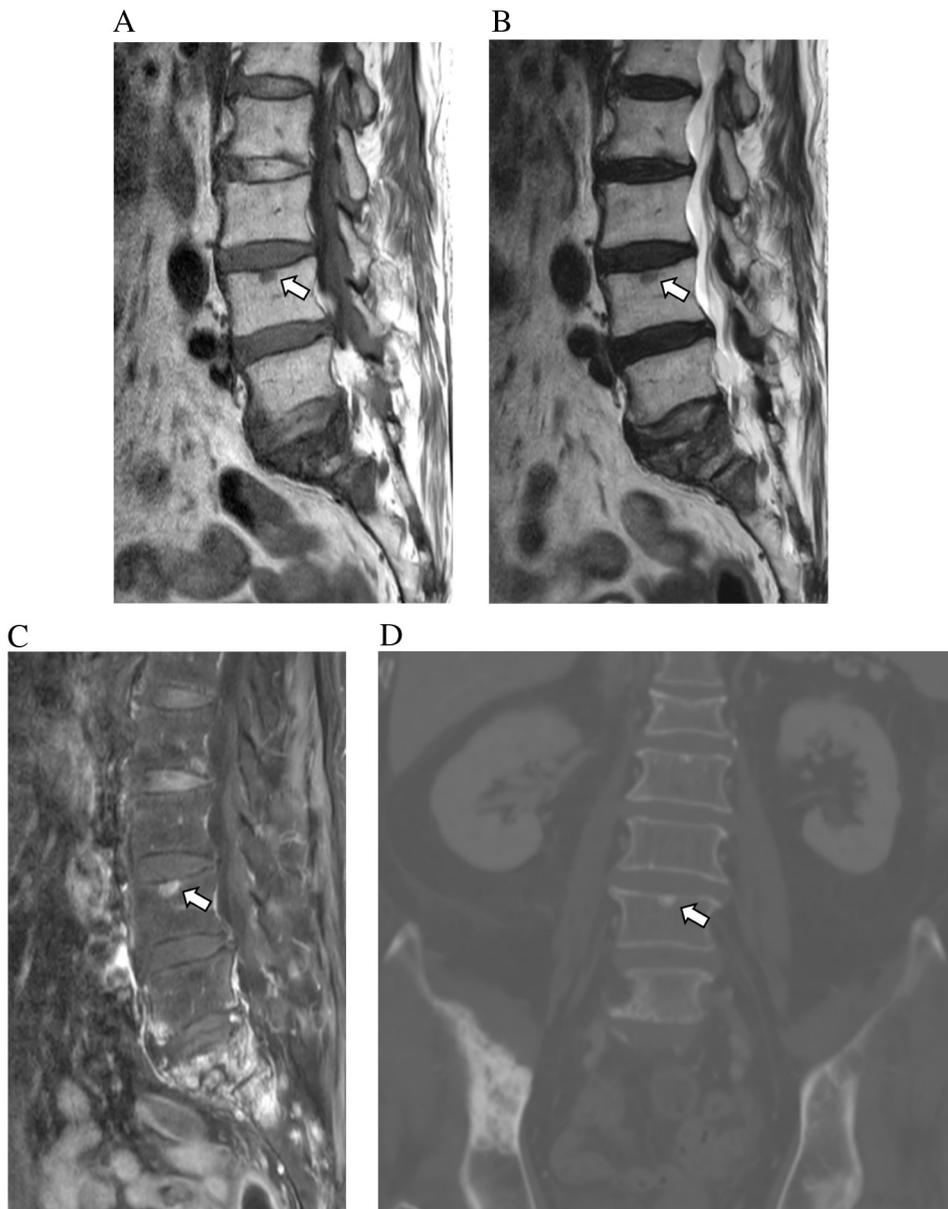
MR images in an 80-year-old man with lung cancer. A, B. Sagittal T1-weighted (A) and sagittal T2-weighted (B) turbo spin-echo MR images show a hypointense lesion at the upper endplate of the L4 vertebral body (arrow) and upper sacrum. C. Sagittal fat-suppressed contrast-enhanced T1-weighted image shows enhancement of the L4 (arrow) and upper sacral lesions. D. Coronal computed tomography reformatted image shows a sclerotic lesion at the L4 vertebral body (arrow) and right pelvic bone. The masses were concluded to be osteoblastic metastases. All three readers interpreted the L4 lesion as equivocal metastasis during session 1 (reading of T1- and T2-weighted images) and as probable metastasis during session 2 (reading of contrast-enhanced images in addition to conventional images). The reading category was classified as category 4 (increased number of probably metastatic segments, decreased number of equivocal segments, no change of probably benign segments during session 2, with reference to session 1; useful in characterization of metastasis) and the degree of usefulness of contrast-enhanced imaging was determined as definitely helpful. All three readers recorded the subjective overall usefulness as 2, the highest score.
